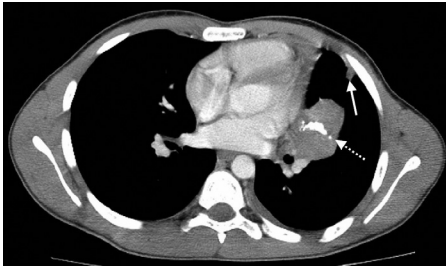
A 15-year-old boy with inflammatory myofibroblastic tumor. The axial contrast-enhanced computed tomography image shows a lobulated mass with heterogeneous enhancement and calcifications (dashed arrow) in the left upper lobe. Note the subpleural atelectasis (arrow).
